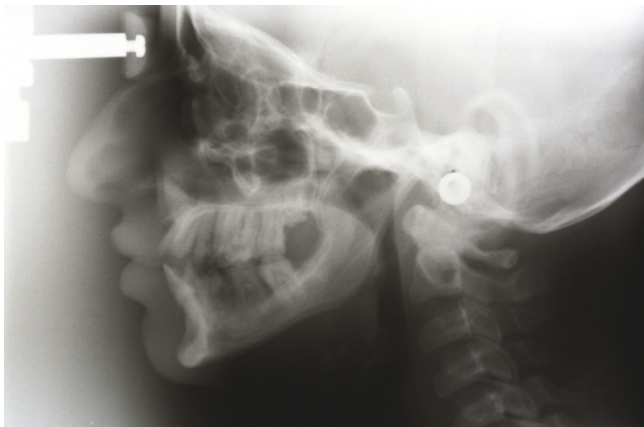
Lateral Cephalometric radiography.
